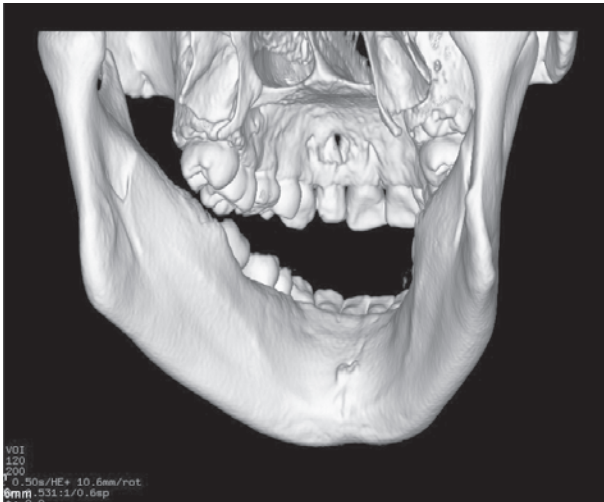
Bony lesion was evident on the CT, which eroded palatal and labial cortical plate.
